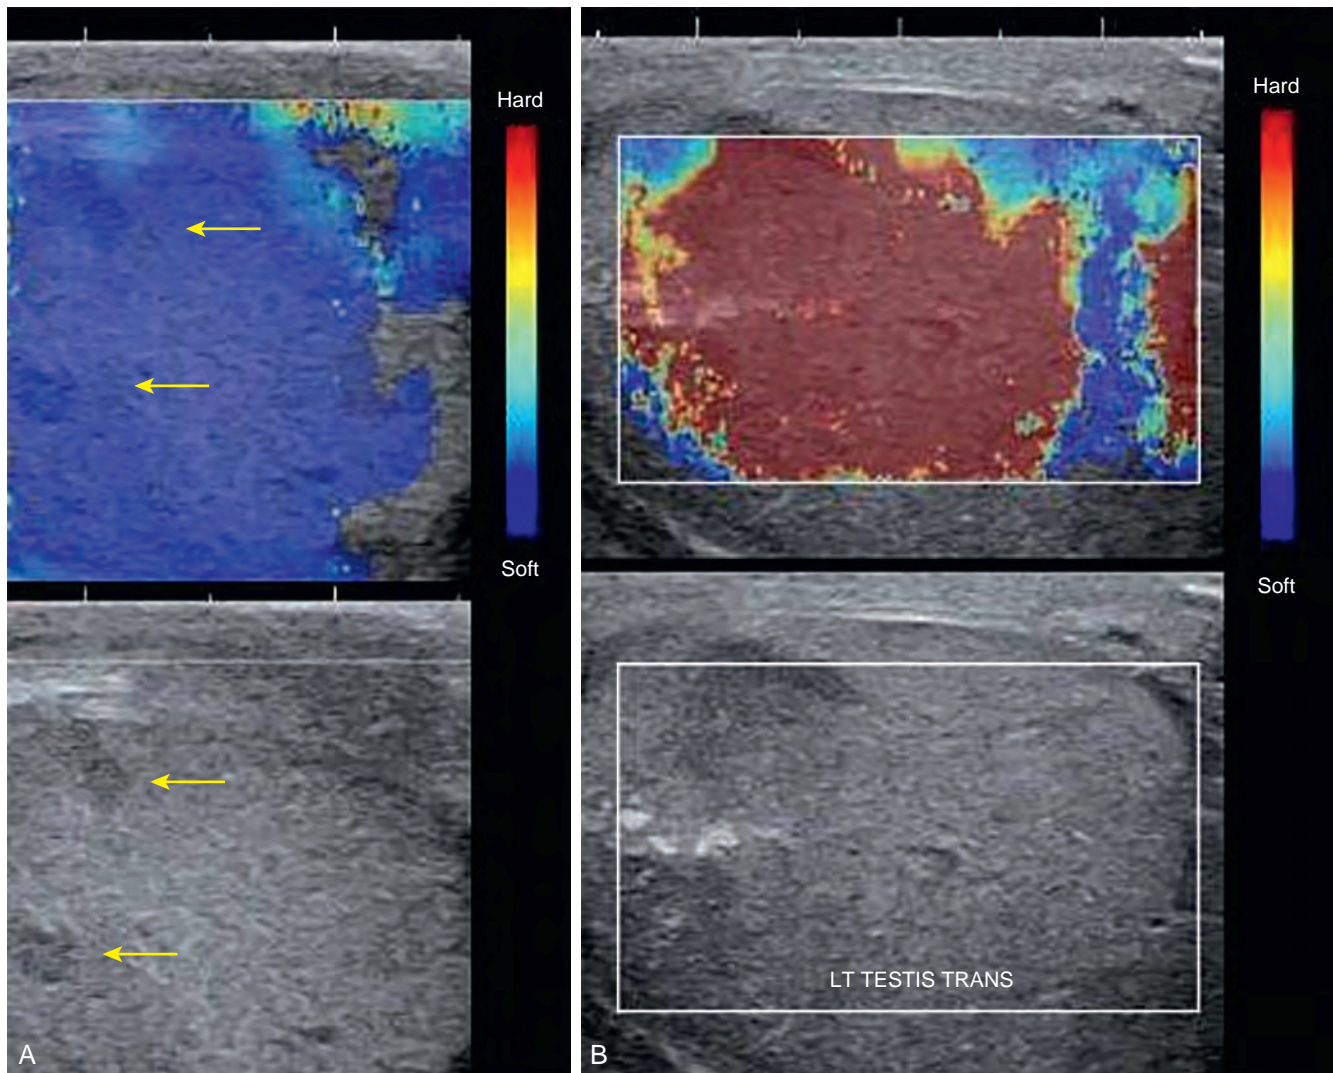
Shear wave elastography (SWE). A, Two small hypoechoic vascular lesions (arrows, lower panel) found with B-mode ultrasonography are shown in the upper panel to be soft (blue) lesions with SWE ultrasonography. Biopsy confirmed a Sertoli cell nodule. B, A larger lesion with heterogeneous echogenicity on B-mode ultrasonography (lower panel) demonstrates diffuse “hardness” on SWE (upper panel). Pathology demonstrated a nonseminomatous germ cell tumor.
